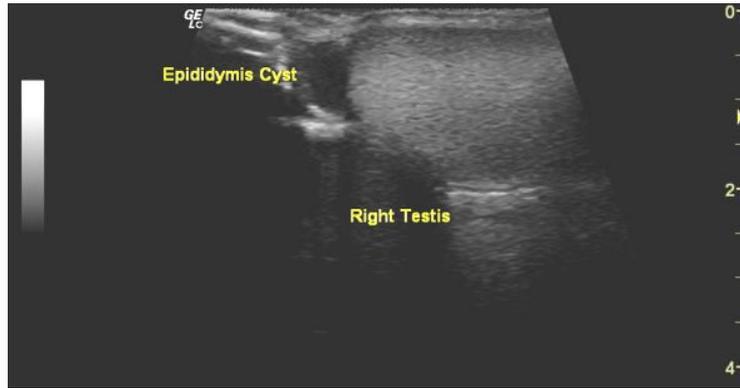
Images of ultrasound scanning of epididymis with cyst in two different subjects.
